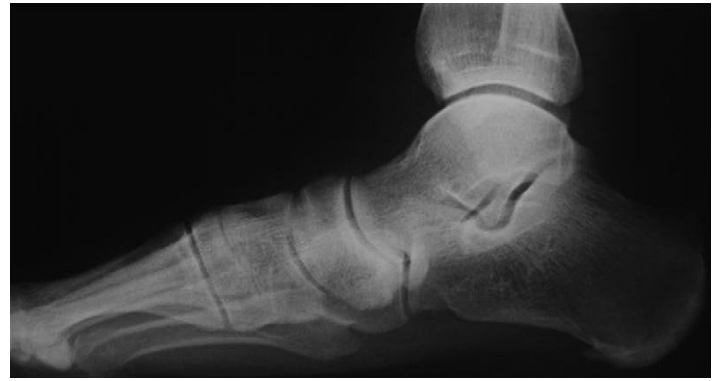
Preoperative lateral radiograph of a 68-year-old female who presented with a painful collapsed pes valgus deformity. A decreased calcaneal inclination angle is visualized in addition to an increase in the talar-first metatarsal angle.
